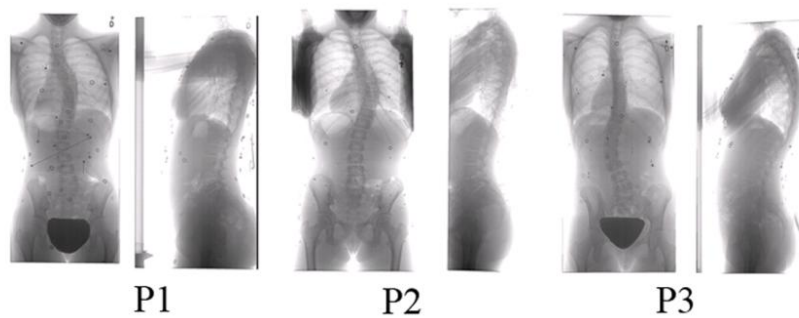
Article 5 Figure 2: Postero-anterior and lateral radiographs of the patients
